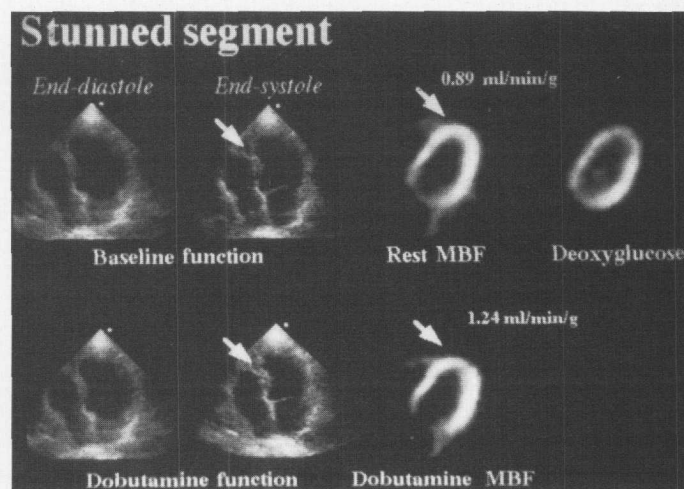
Echocardiographic and tomographic findings in myocardial stunning. The analysis of baseline wall motion (top left) shows septal akinesis improving during dobutamine administration (bottom left). PET study (right) revealed that the septal dysfunction was associated with a preserved perfusion (resting MBF) and deoxyglucose uptake raising the picture of stunned myocardium.
